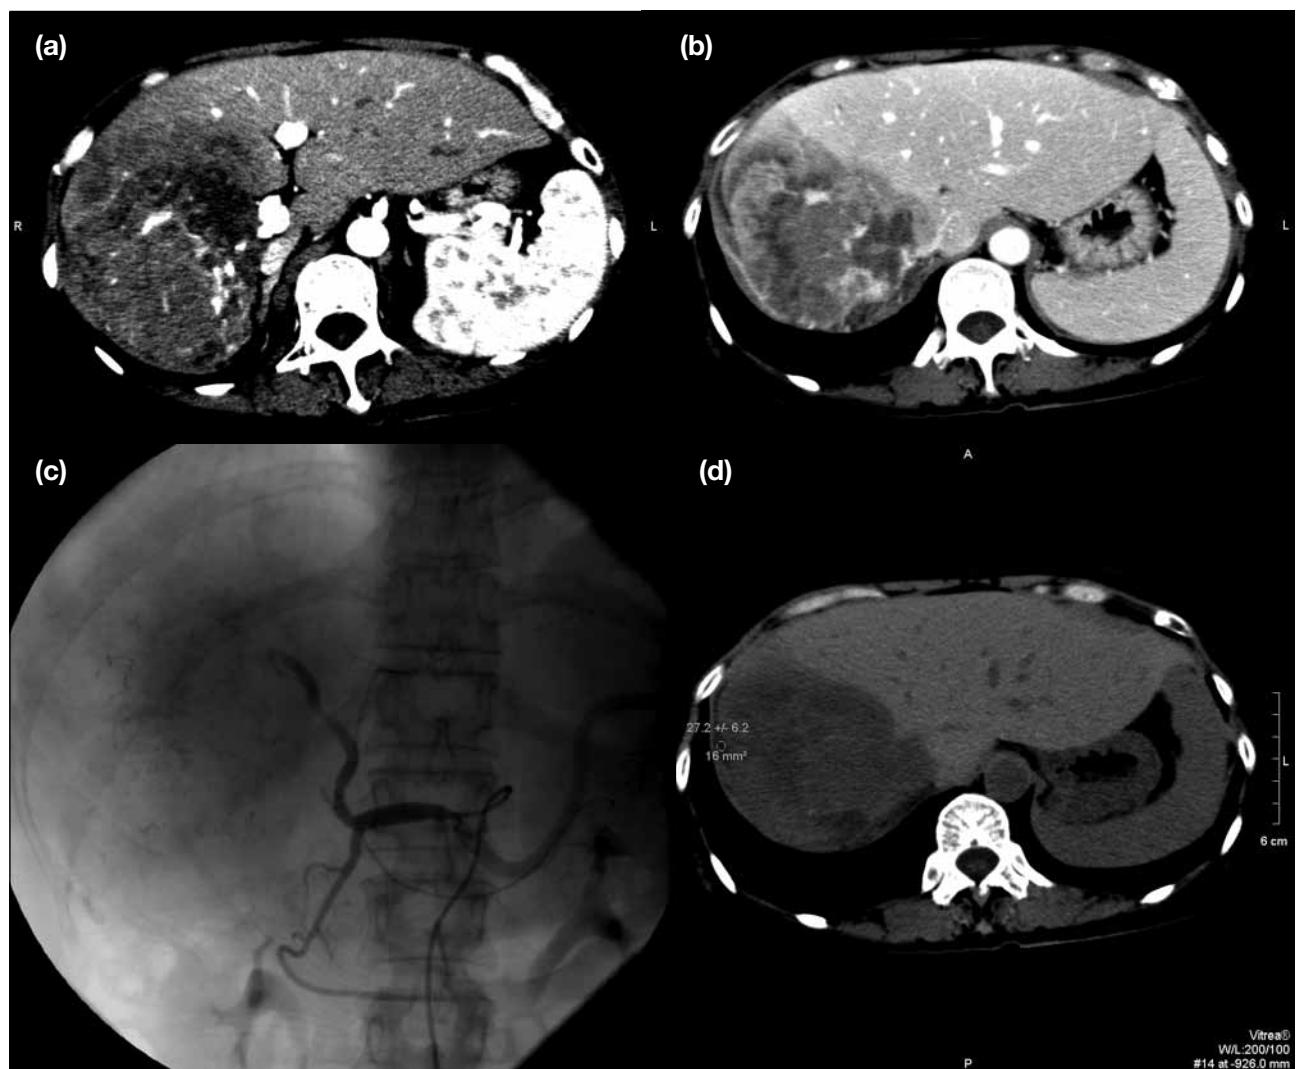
Post-contrast axial computed tomographic (CT) scan of the liver in (a) the arterial phase and (b) the portovenous phase showing a large hypervascular mass lesion in the right lobe and medial segment of the left lobe of the liver. (c) Conventional angiography with cannulation of the common hepatic artery shows an area of hypervascularity in the right lobe of the liver. (d) Non-contrast CT shows a rim of subcapsular fluid with a slight increase in density, suggestive of subcapsular haemorrhage.
